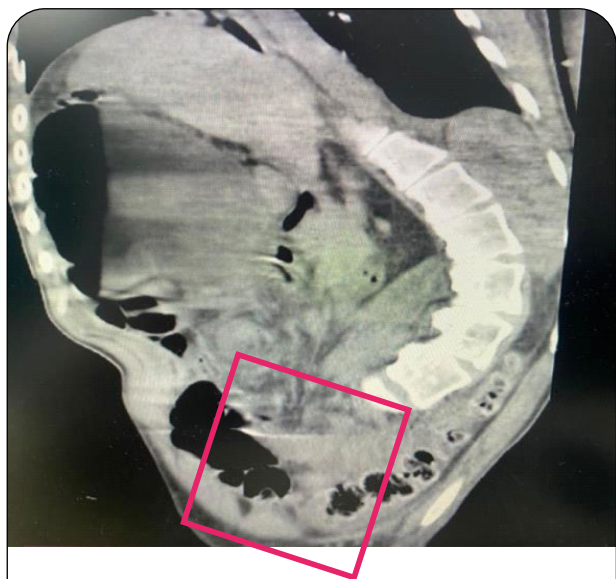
Simple CT scan of the abdomen and pelvis. Sagittal section with "vortex" imagery in the right iliac fossa.
